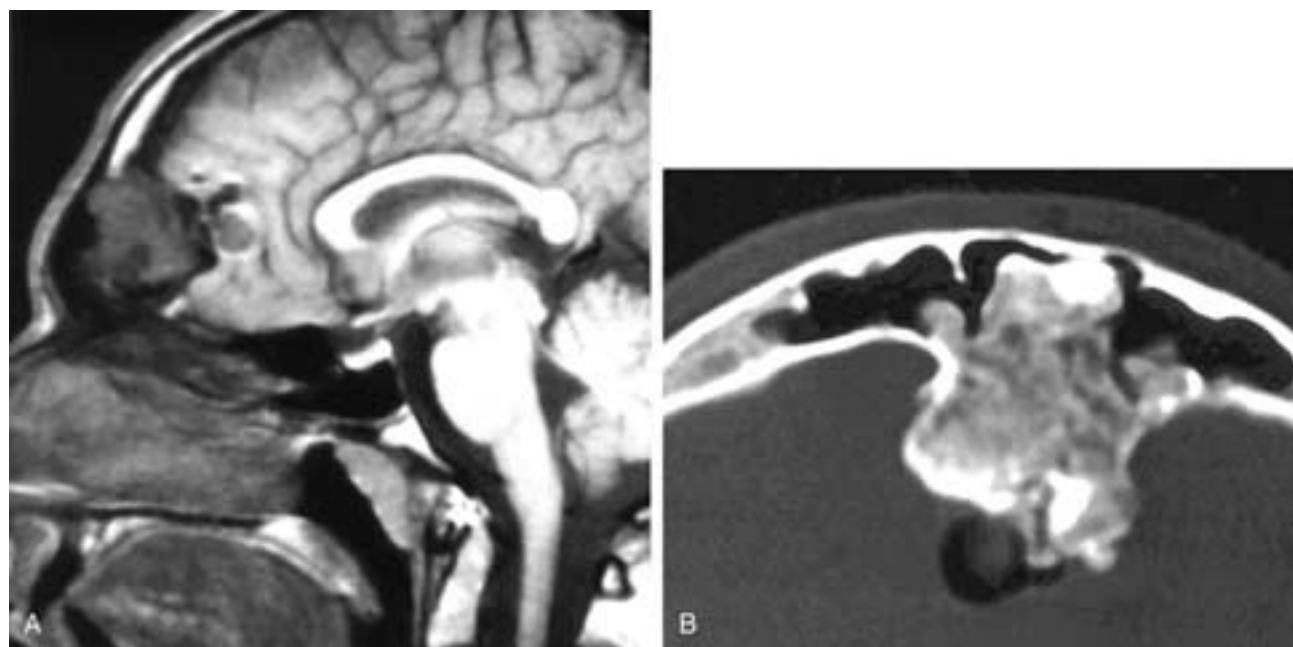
Sagittal T1-weighted MR image (A) and axial CT scan (B) show an osteoma arising from the posterior frontal sinus wall and extending intracranially. A small amount of air is seen in the adjacent frontal lobe region. Notice how much more clearly this diagnosis can be established on CT. In A, this could just as easily be a nonossified cellular tumor.
